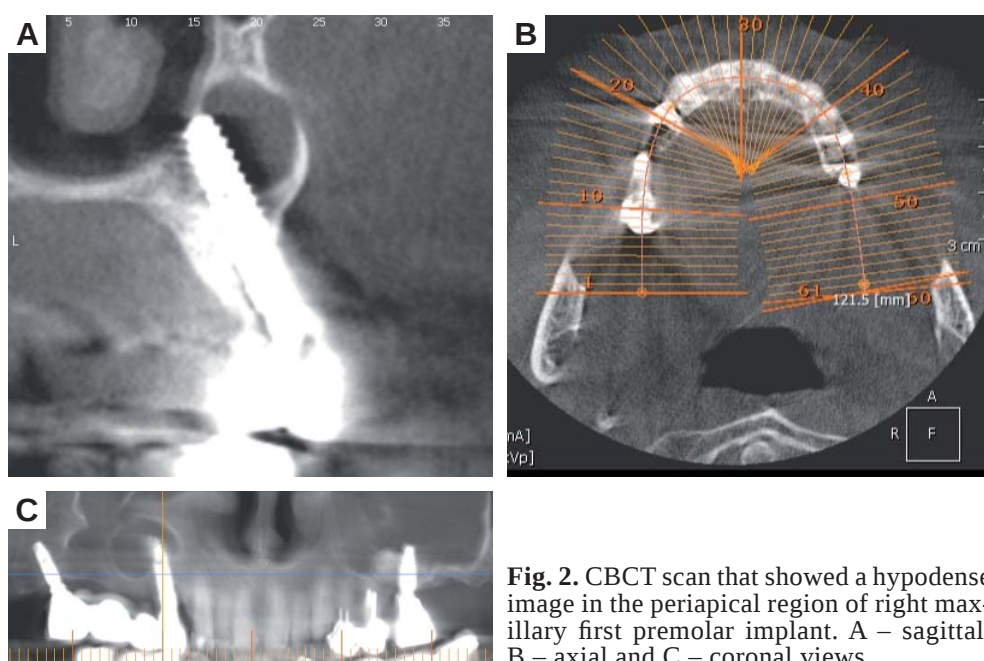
CBCT scan that showed a hypodense image in the periapical region of right maxillary first premolar implant. A – sagittal, B – axial and C – coronal views.
